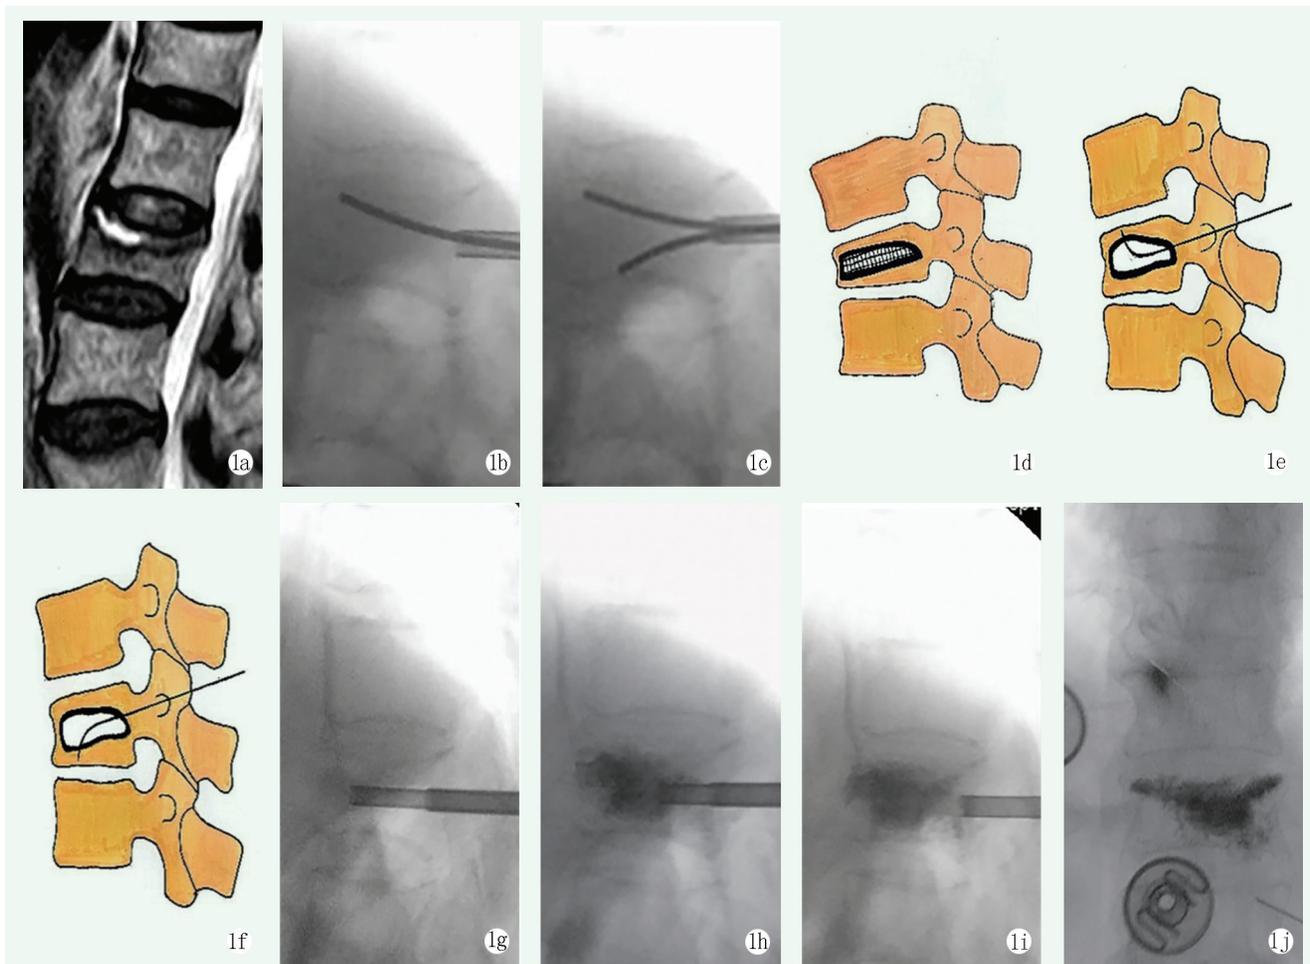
A-PKP 手术操作。1a~1c: MRI 提示 IVC 靠近头端终板, 采用“Out-In”技术, 一枚弯头克氏针由周围硬化带向 IVC 内做多次穿刺, 在硬化带上形成多个微穿刺点, 另一枚弯头克氏针向相反侧终板穿刺, 在周围松质骨内形成骨水泥弥散通道, 以便骨水泥锚定并接触终板; 1d~1f: 当 IVC 位于椎体中央时, 采用“in-out”技术, 一枚弯头克氏针朝向上终板, 由 IVC 内向周围硬化带多次穿刺, 另一根克氏针则朝向下终板, 做相同穿刺; 1g: 于 IVC 前端注射面团期早期骨水泥“封堵”; 1h: 于 IVC 中注入拉丝早期骨水泥, 弥散于 IVC 及其周围松质骨; 1i: 注入拉丝晚期骨水泥并锚定于前一阶段注入的骨水泥; 1j: 骨水泥弥散于椎体内, 形成多个“锚定点”。
